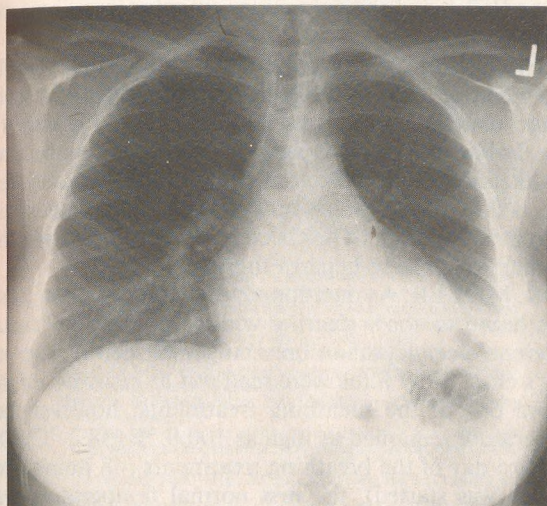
Initial chest x-ray film obtained when decreased breath sounds were noted on her left thorax. The elevated left hemidiaphragm, mediastinal shift to the left, and anterior herniation of the right lung indicate marked loss of volume of the left lung, probably due to total obstruction of the left main bronchus, eg, a mucous plug
